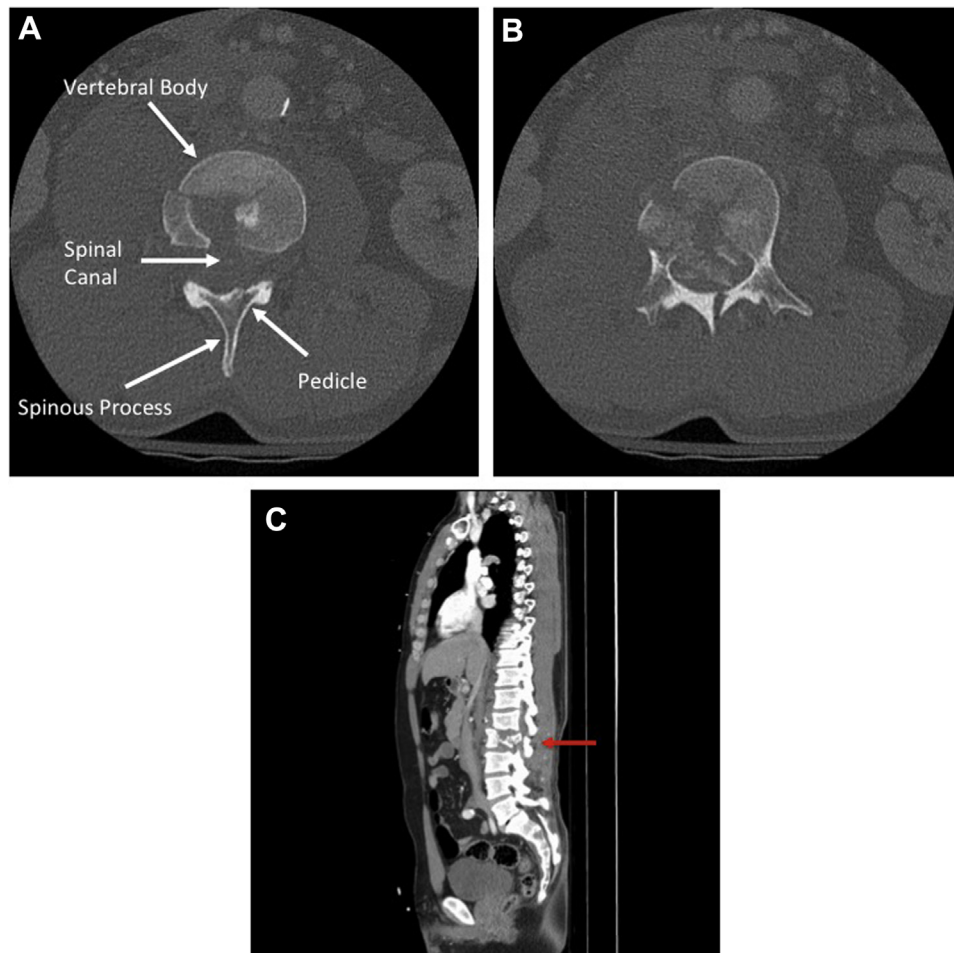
(A) A CT scan of the lumbar spine revealing fractures of L1 and L2 with severe comminuted compression deformity and retropulsion of fragments of L2 into the central canal. (B) A CT scan of the lumbar spine revealing fractures of L1 and L2 with severe comminuted compression deformity and retropulsion of fragments of L2 into the central canal. (C) A CT scan of the lumbar spine revealing fractures of L1 and L2 with severe comminuted compression deformity and retropulsion of fragments of L2 into the central canal.
